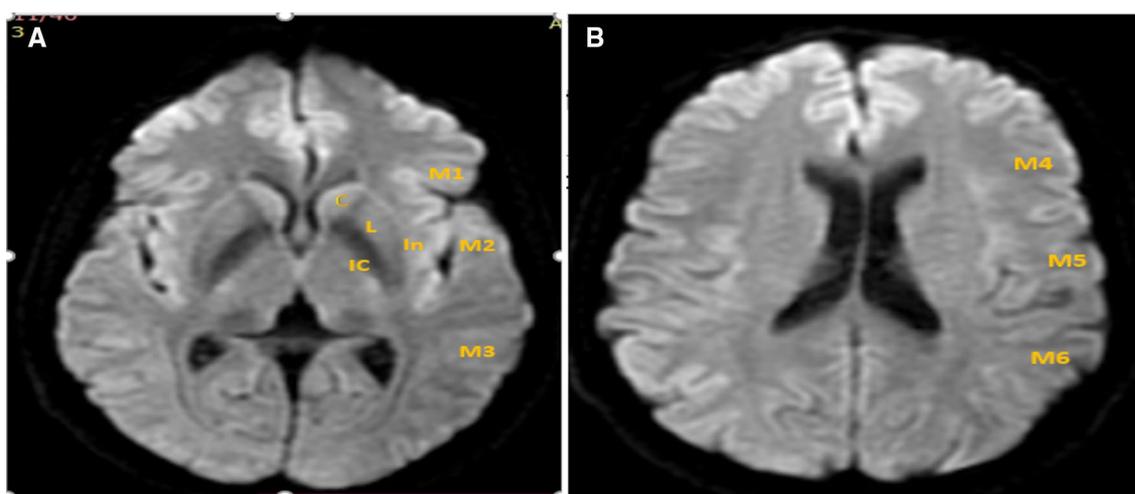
Alberta Stroke Program Early CT Score (ASPECTS) in diffusion weighted imaging. A axial DWI at the level of the basal ganglia showing seven areas assessed in ASPECTS including caudate nucleus (C), insular ribbon (In), internal capsule (IC), lentiform nucleus (L), anterior middle cerebral artery (MCA) cortex (M1), MCA cortex lateral to the insular ribbon (M2), and posterior MCA cortex (M3). B Axial DWI at supraganglionic level showing the other three areas assessed in ASPECTS including M4, M5 and M6 which are the anterior, lateral, and posterior MCA territory immediately superior to M1, M2, and M3
